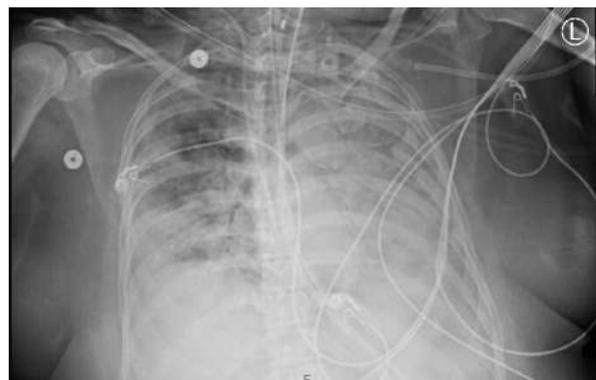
This chest x-ray image is an anteroposterior (AP) view denoting bilateral interstitial and alveolar opacities, left side more prominent than the right side. Almost confluent alveolar opacities are noted on the left side with accompanying pleural effusion, suggestive of a left-sided pneumonia as the suggestive etiology for ARDS.
